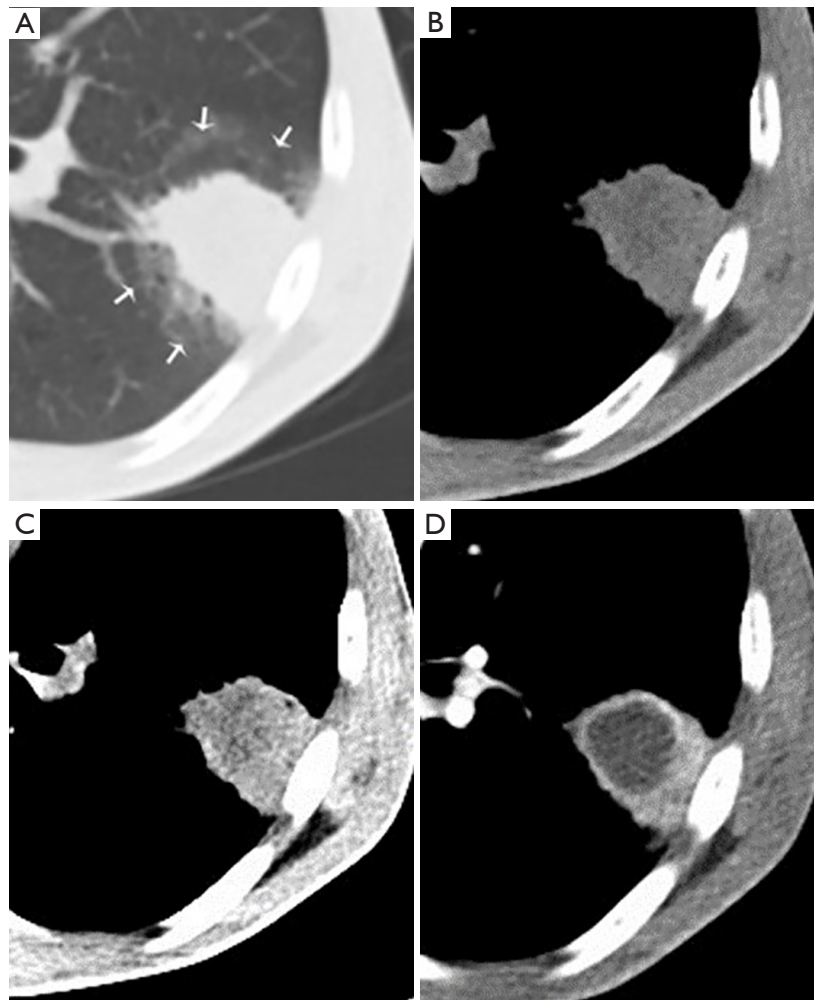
CT images of an inflammatory lesion. The plain CT scan shows an oval and well-defined mass with a halo sign (white arrow) in the left lower lobe (A); and an ill-defined focal area with slightly lower attenuation is detected in the mass on standard and narrow mediastinal window (B,C). A well-defined, and round HyS with Δ CT of 5.0 HU can be observed on the contrast-enhanced image (D). Δ CT = peak CT value measured on enhanced images - CT value measured on plain CT scan. CT, computed tomography; HyS, hypodense sign; HU, Hounsfield units.
